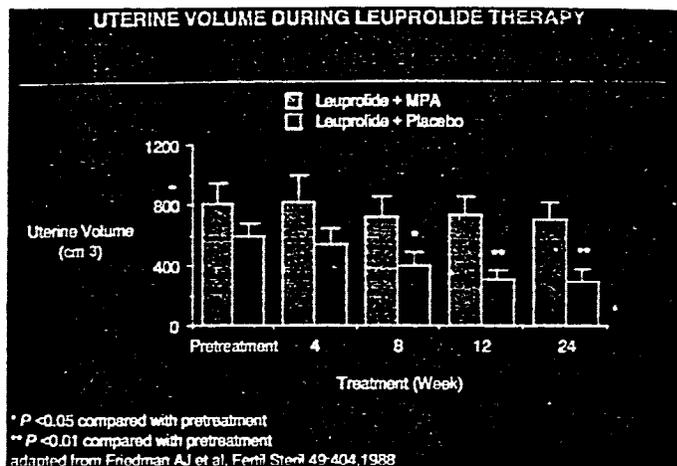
Effect of concurrent progestin (MPA)-only 'add-back' on the ability of leuprolide to reduce the sonographically monitored uterine volume. Adapted from Friedman *et al.* (1988).
